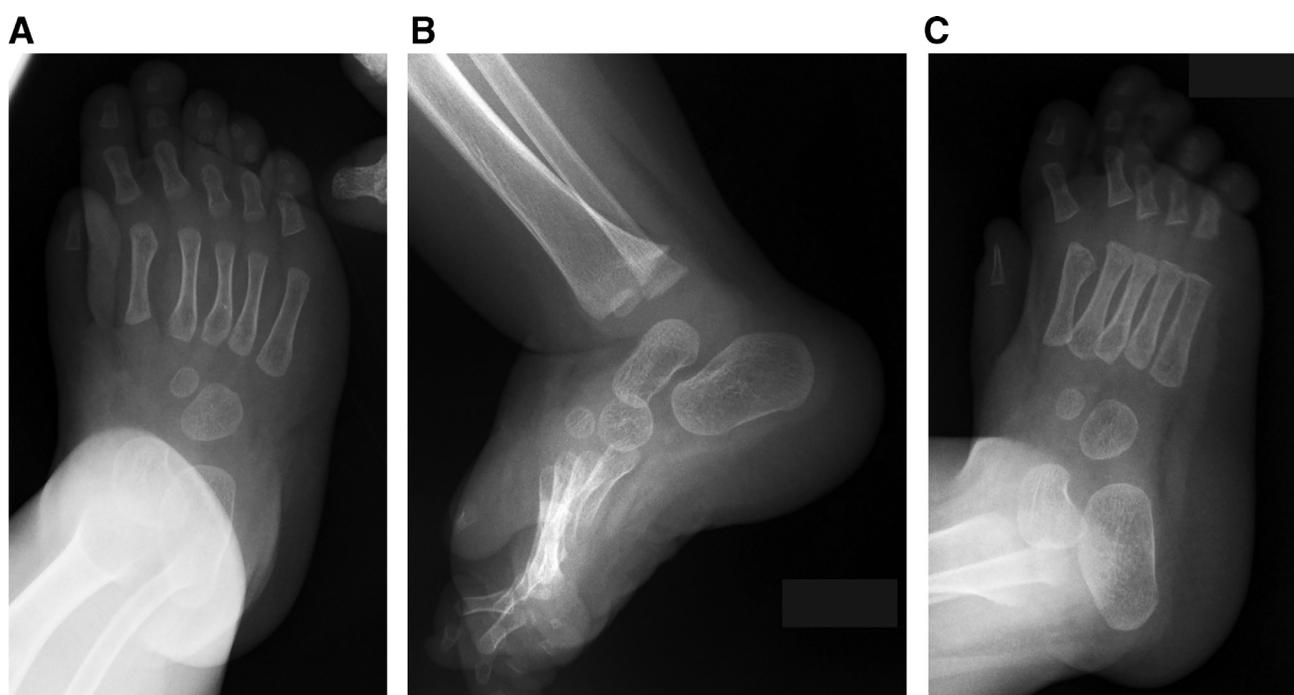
Patient 2, preoperative radiographs. Anteroposterior (A), lateral (B), and oblique (C) radiographs of the right foot at age 12 months.
